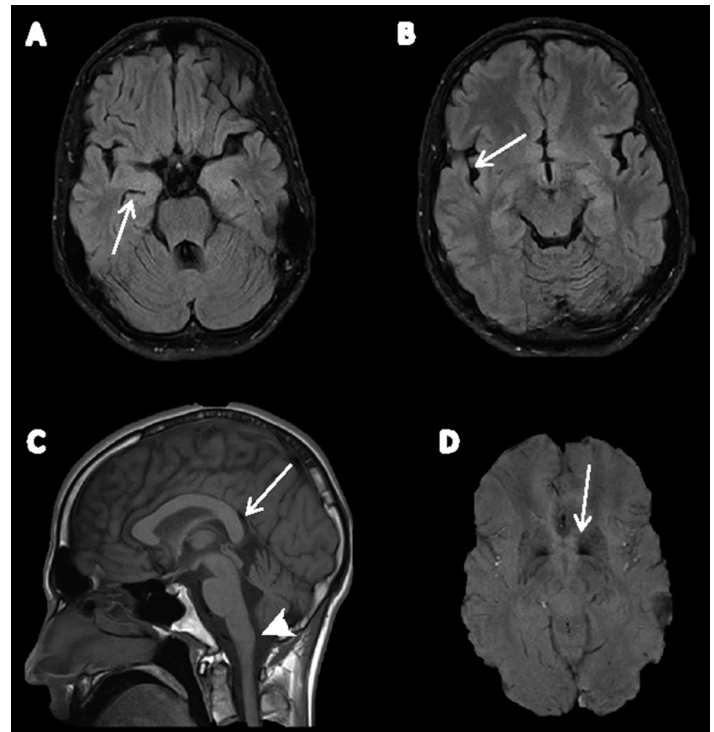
Brain Magnetic Resonance Imaging of Patient with PLA2G6-associated Dystonia–Parkinsonism. (A,B) Axial fluid-attenuated inversion recovery images show frontotemporal atrophy with widened temporal horns of lateral ventricles (arrow in A) and lateral fissure (arrow in B). (C) Mid-sagittal T1 image shows vertically oriented splenium (arrow) and apparent claval hypertrophy (arrowhead). Mild cerebellar vermis atrophy is also visible. (D) SWI demonstrates bilateral hypointensity in the globus pallidus due to iron deposition (arrow).
